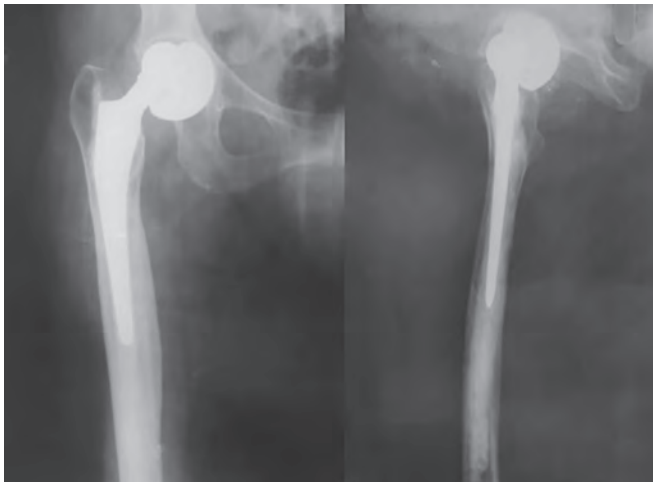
Preoperative X-ray showing component dissociation with inferomedial displacement of acetabular component
